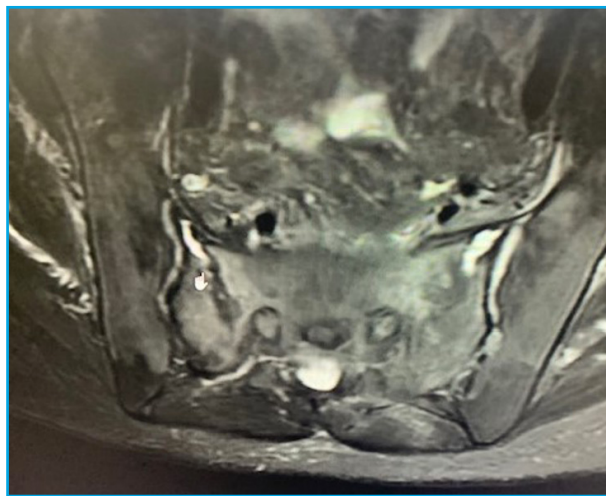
MRI image in a T2 fat-suppressed sequence.
